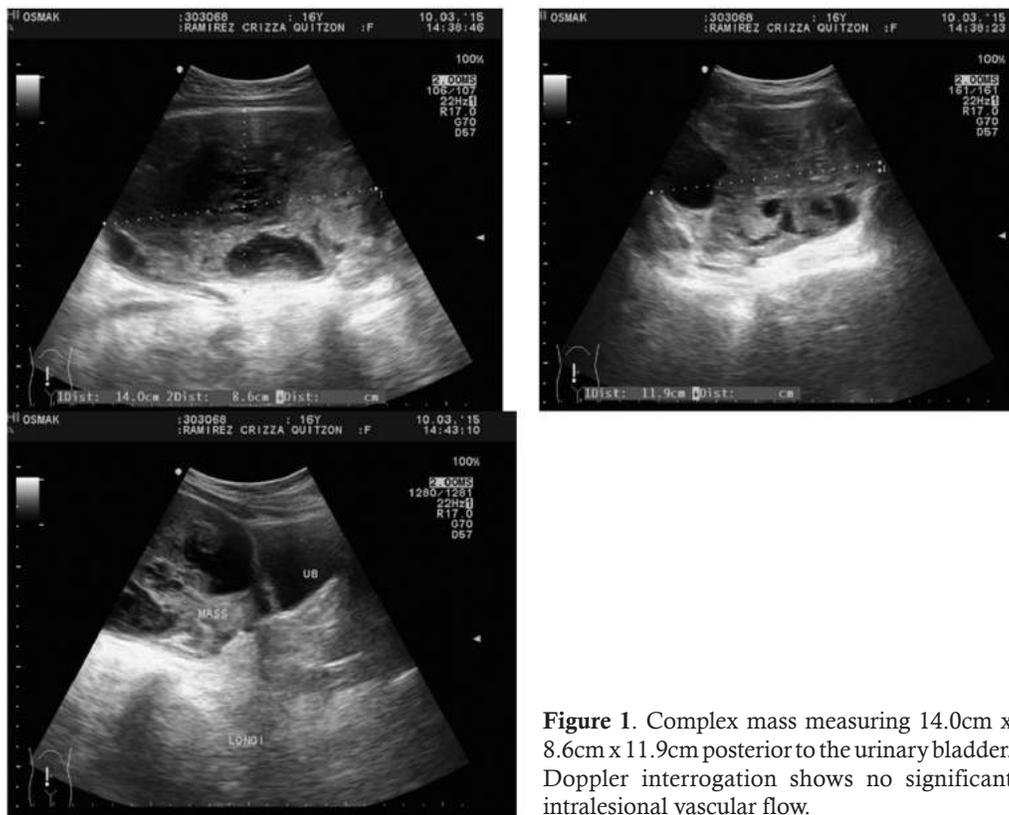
Complex mass measuring $14.0 \text{ cm} \times 8.6 \text{ cm} \times 11.9 \text{ cm}$ posterior to the urinary bladder. Doppler interrogation shows no significant intralesional vascular flow.
